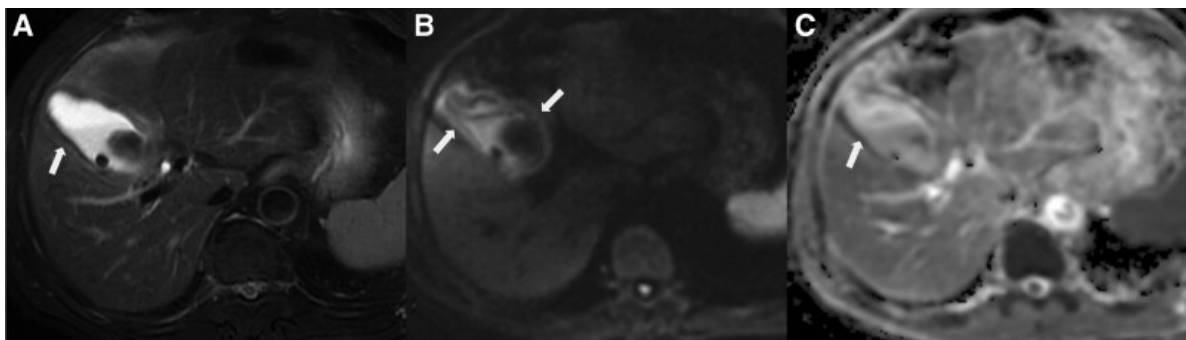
(a-c): Xanthogranulomatous cholecystitis (XGC) in a 60-year-old male, (a) T2WI fat-sat shows diffuse gallbladder wall thickening without layered appearance, with inner margin hypointensity and no papillary growth, (b) DWI demonstrates diffuse hyperintensity with layered appearance, (c) ADC map reveals inner margin hypointensity
